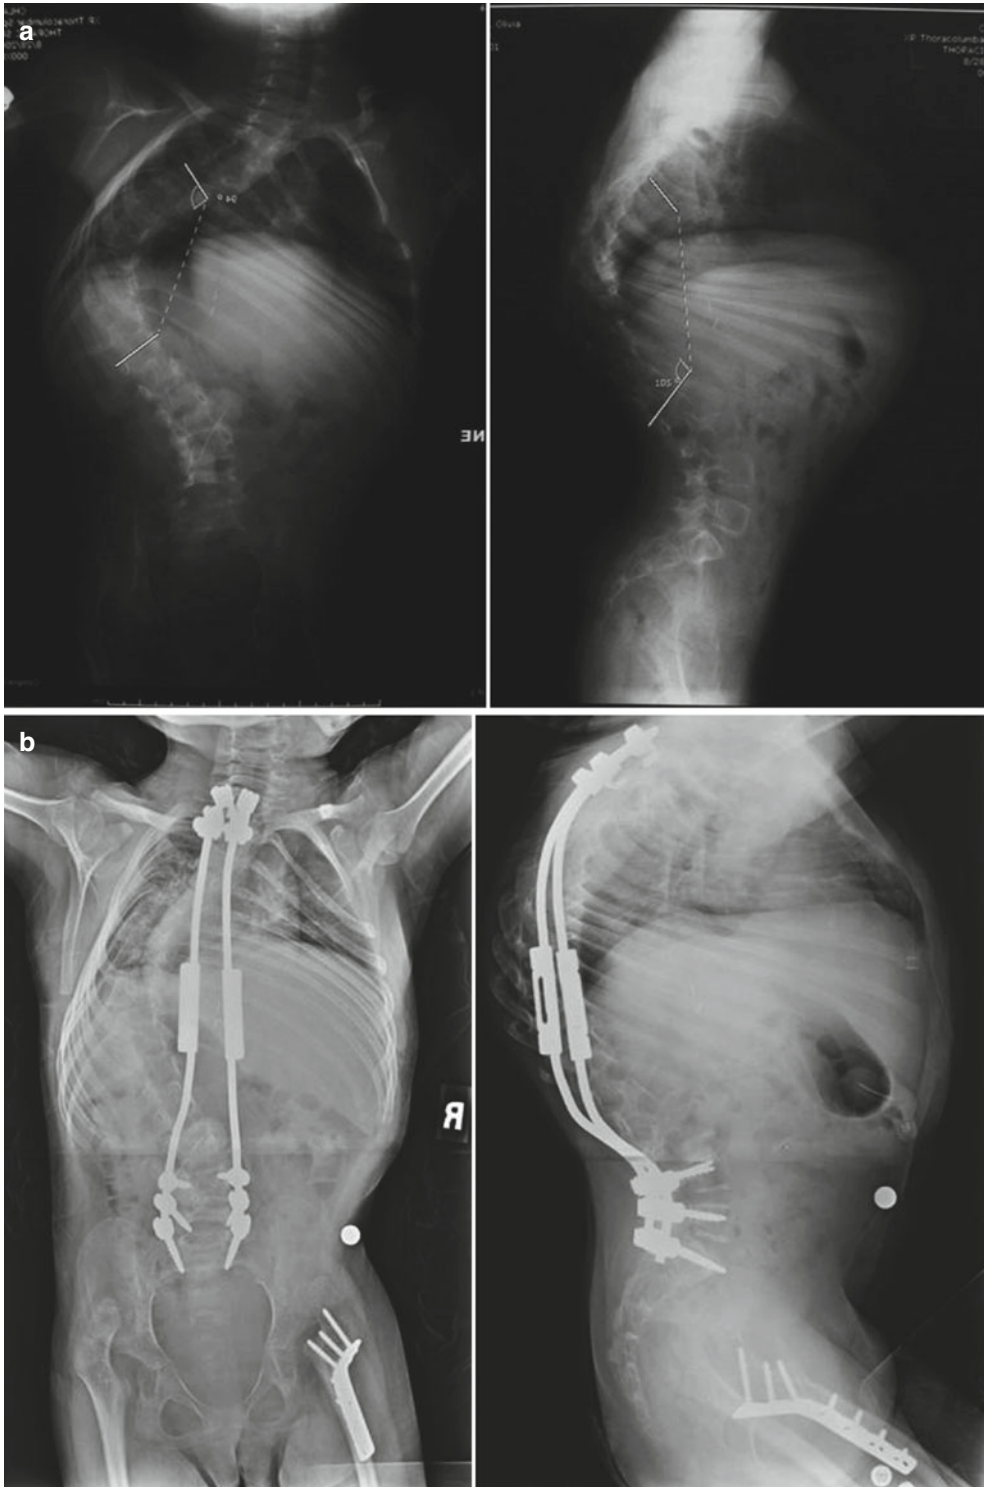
Dual growing rods in a patient with severe kyphoscoliosis. (a) Postoperative radiographs show considerable correction after surgery and proper contouring to accommodate kyphosis (b)
